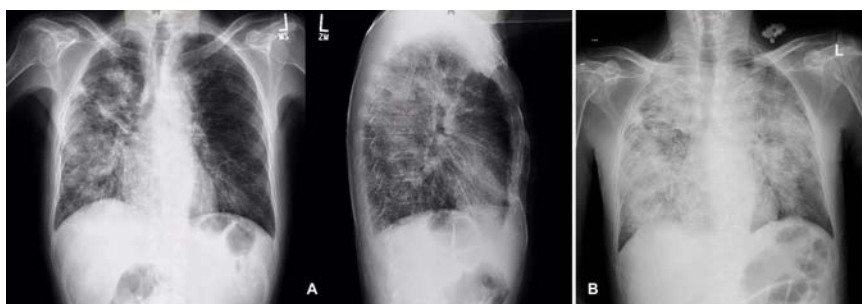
A) Chest X-ray (AP/Lat) at the time of admission (day 1); B) chest X-ray (portable film) showing extensive infiltrates bilaterally (day 3).
